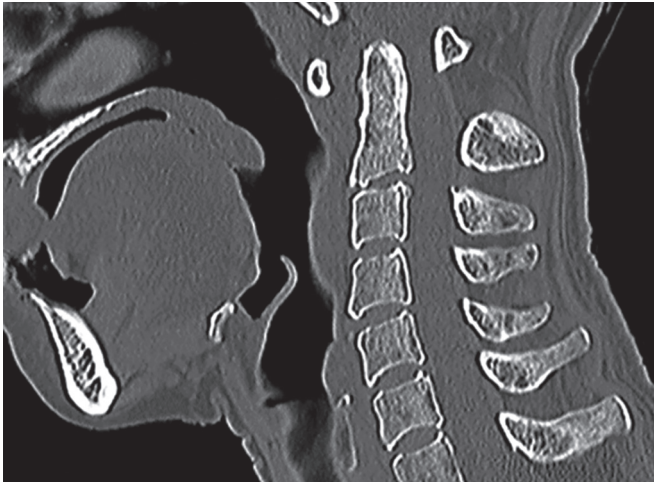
Preoperative CT showing no congenital anomaly in C1 to C2 joint
